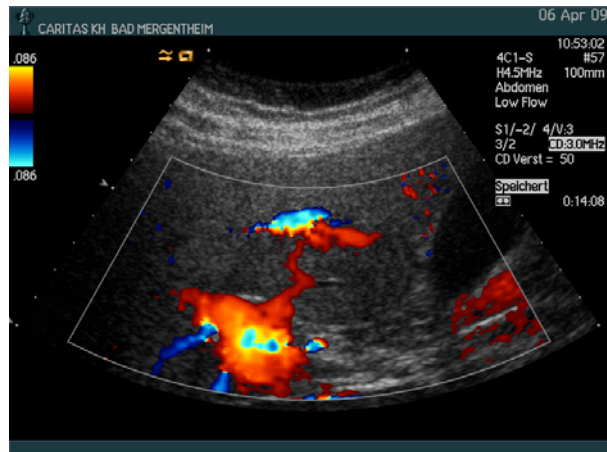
Hepatic steatosis. Perhaps the most objective and therefore most important sign of hepatic steatosis are circumscribed focal hypoechoic areas in the liver hilum examined in a left posterior oblique position. B-mode ultrasound demonstrates a focal liver lesion in between callipers(a). Colour Doppler imaging indicates a centrally located vessel of undetermined origin (b). CEUS showed the typical enhancement pattern. Typically a centrally located arterial vessel can be displayed [(32;38)] in the arterial phase (c, arrow) and a portal vein branch in the portal venous phase (d, arrow) and homogenous enhancement in the late phase [(38)].
